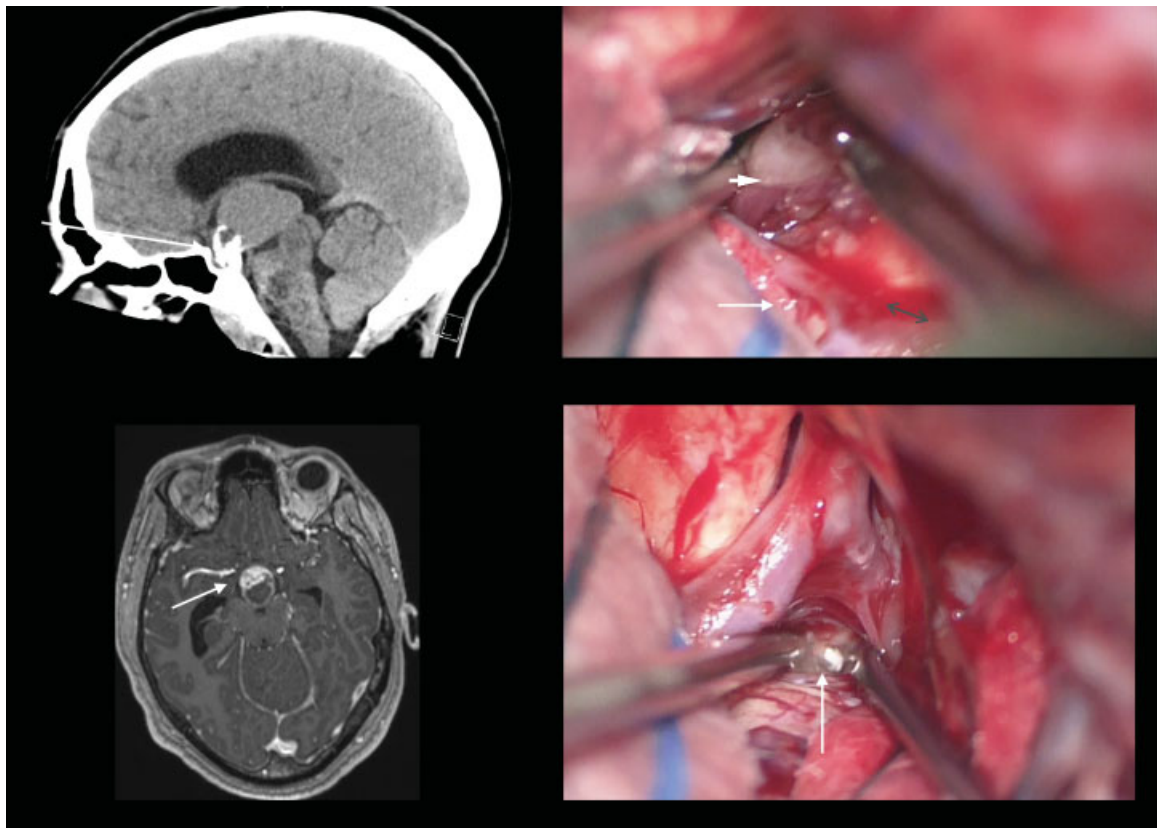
(A) Through a right transylvian approach, the tumor is removed from the lamina terminalis (arrowhead). The right A1 (white arrow) and chiasma (black arrow) are seen. The CT scan shows the approximate trajectory to access the third ventricular component. (B) The suprasellar component is seen in the MRI (arrow) and removed between the ICA and PCOM (arrow). CT, computed tomography; ICA, internal carotid artery; MRI, magnetic resonance imaging; PCOM, posterior communicating artery.
